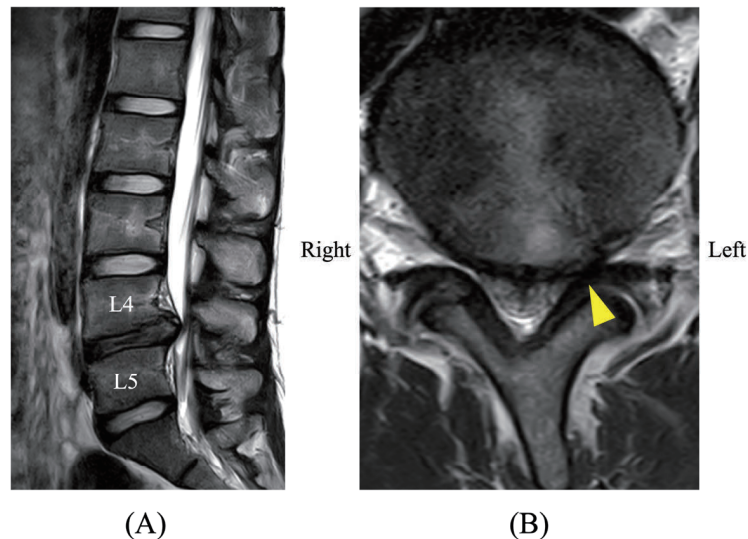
MRI images obtained at our hospital. (A) T2-weighted sagittal image showing posterior disc herniation at the L4/5 level. (B) T2-weighted axial image at the L4/5 level demonstrating left-predominant disc herniation compressing the L5 nerve root (yellow arrowhead).
